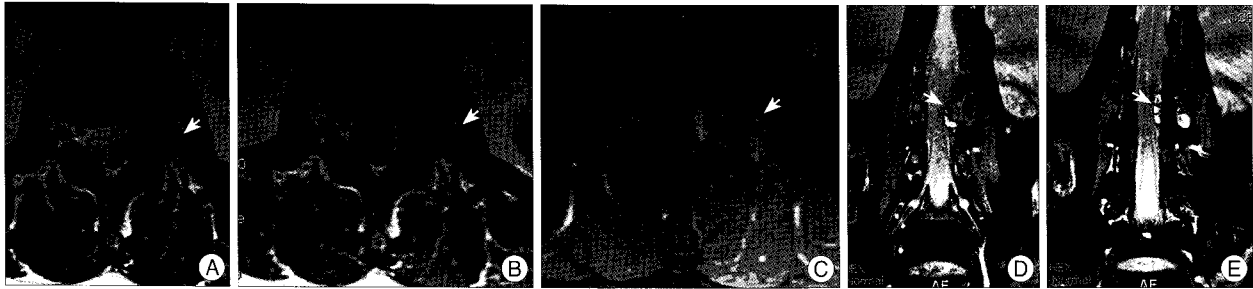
A and B : MR imaging reveals a dumbbell like mass in the intervertebral foramen between second and third lumbar vertebrae on the left side (arrow). C : Gadolinium-DTPA administration increases the signal intensity at the periphery of the mass. D and E : MR coronal view shows multi-loculated extradural cysts in the intervertebral foramina (arrows).
